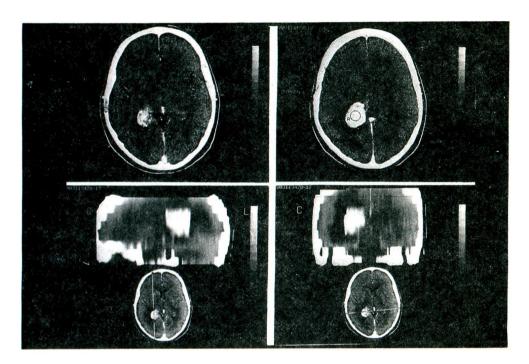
CT scanner of Case 1 revealed a hyperdense mass with multiple calcifications and marked enhancement within the atrium of right lateral ventricle.
